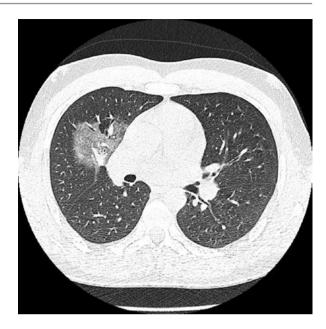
HRCT of the lungs: ground glass opacity (alveolar haemorrhage)
